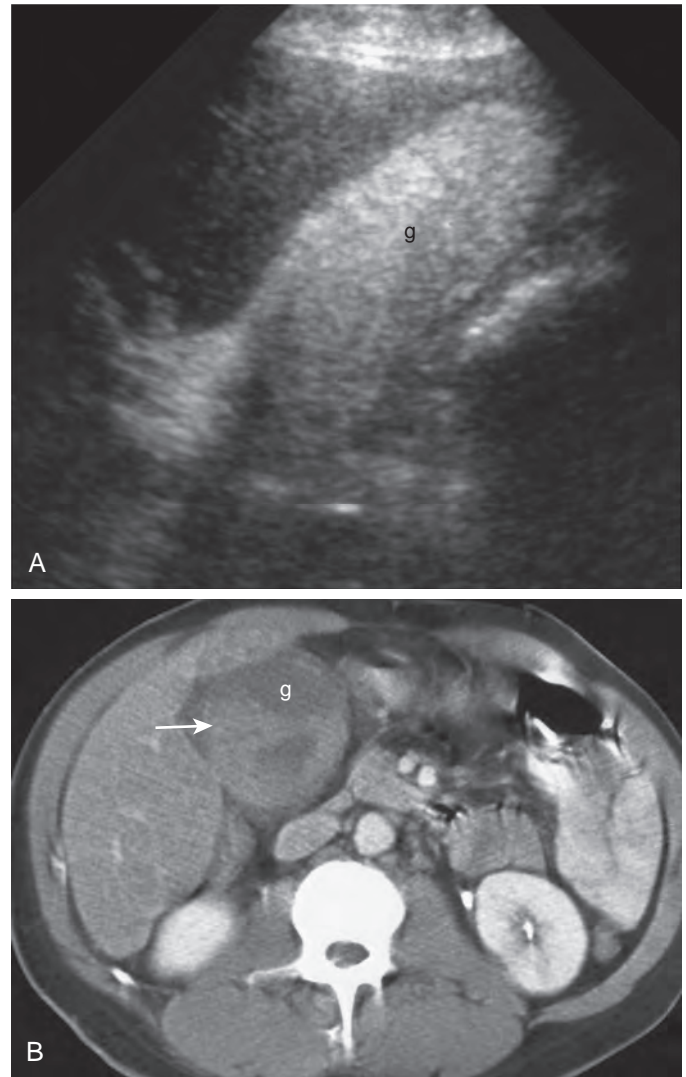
Hemorrhagic cholecystitis: ultrasound and CT findings. A. Sagittal ultrasound scan demonstrates distended gallbladder (*g*) with lumen completely filled with echogenic material corresponding to hemorrhagic bile. B. CT scan demonstrates distended gallbladder (*g*) with fluid-fluid level (arrow) with high-attenuation dependent component. These findings represent intraluminal blood clot.
